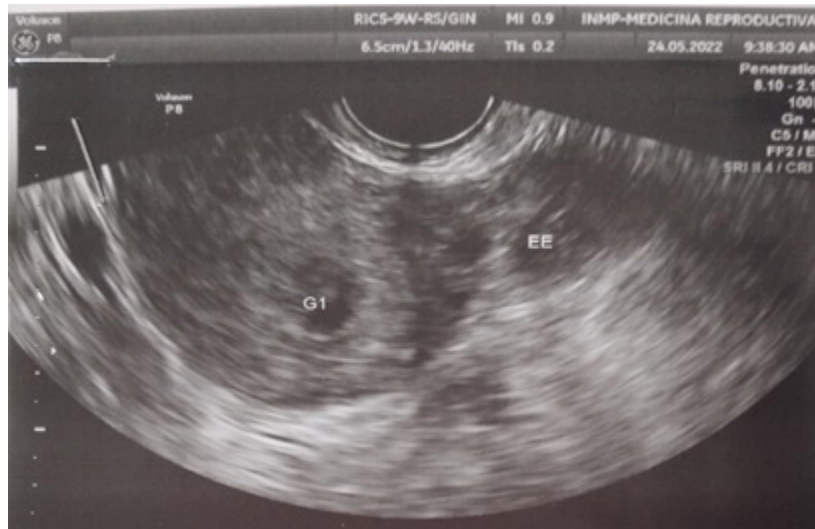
Ultrasound image of heterotopic pregnancy (G1: intrauterine pregnancy, EE: ectopic pregnancy).
